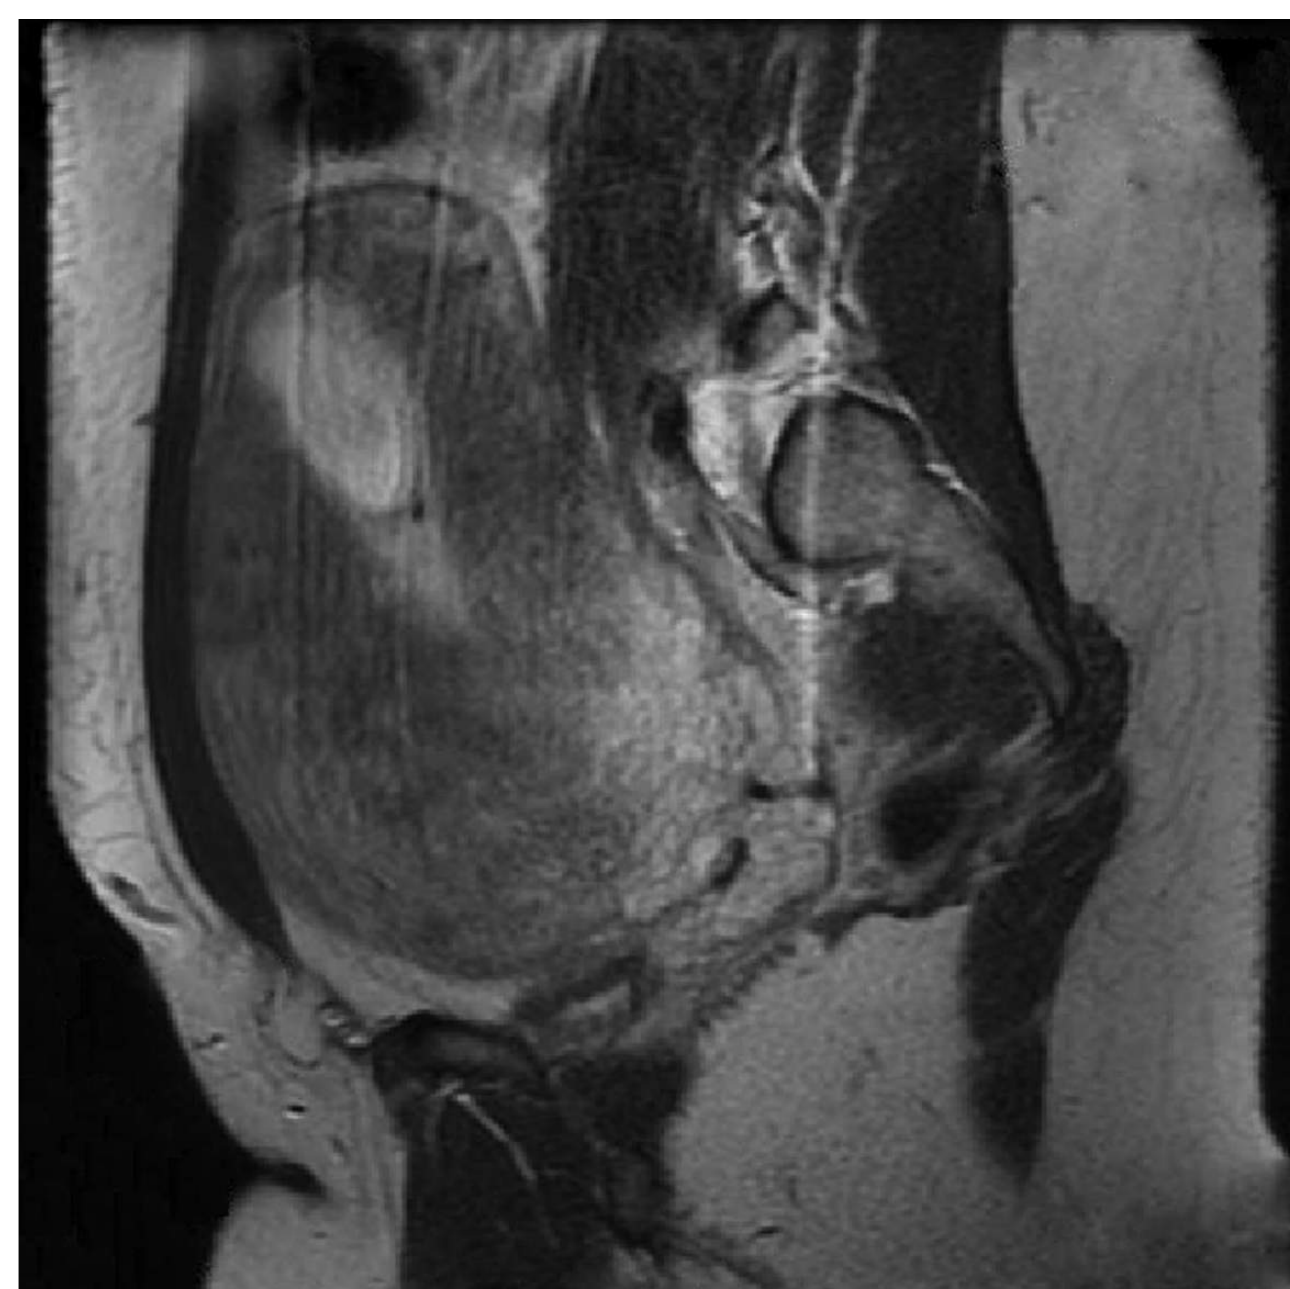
■ Interstitial Ectopic. This MRI confirmed a formal ultrasound of an interstitial ectopic. (Photo contributor: Lauren Oliveira, DO.)
